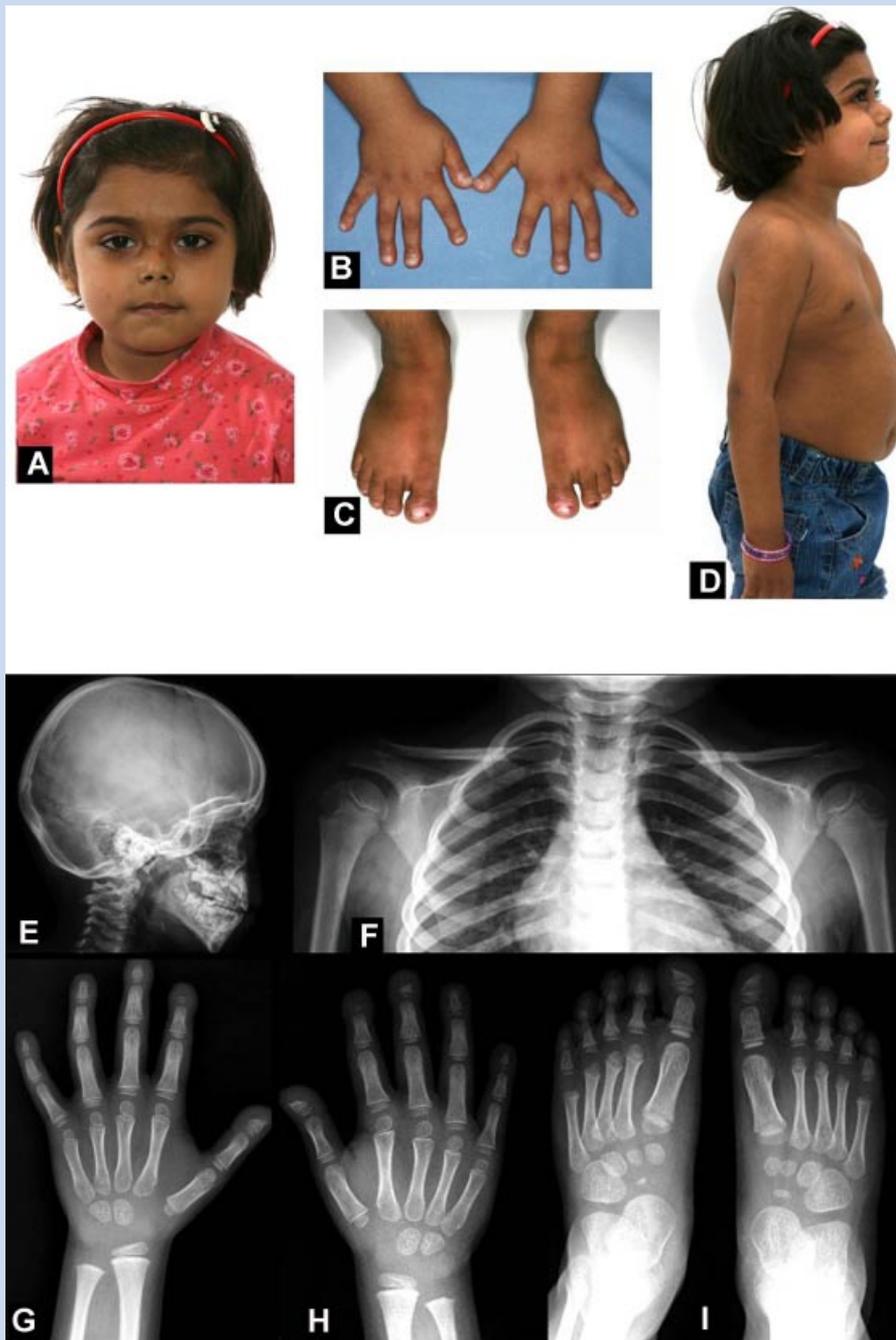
Patient 2. A: Round face and chubby cheeks. B: Hands: short and broad distal phalanges with short nails. C: Feet: broad first toe. D: Prominent abdomen and subcutaneous fat more evident on trunk and abdomen. E: X-rays of the skull—wormian bones. F: X-rays of the thorax—thin clavicles. G–I: Hands and feet X-rays showed short terminal finger and toe phalanges with acro-osteolysis.
